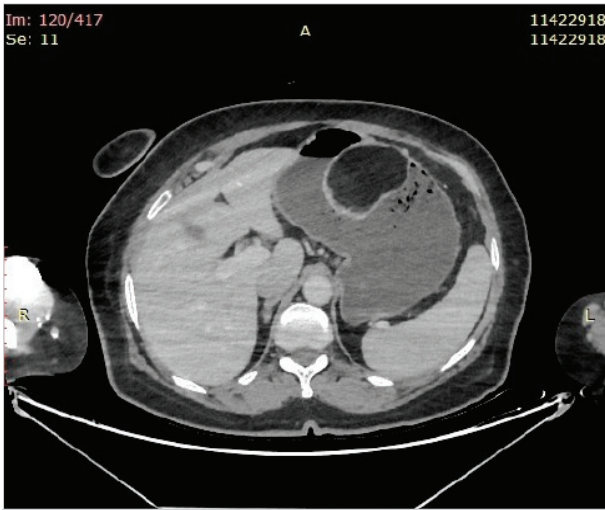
Preoperative CT image. In the gastric corpus, a 6 cm lesion of lipoma density located in the greater curvature is seen.
